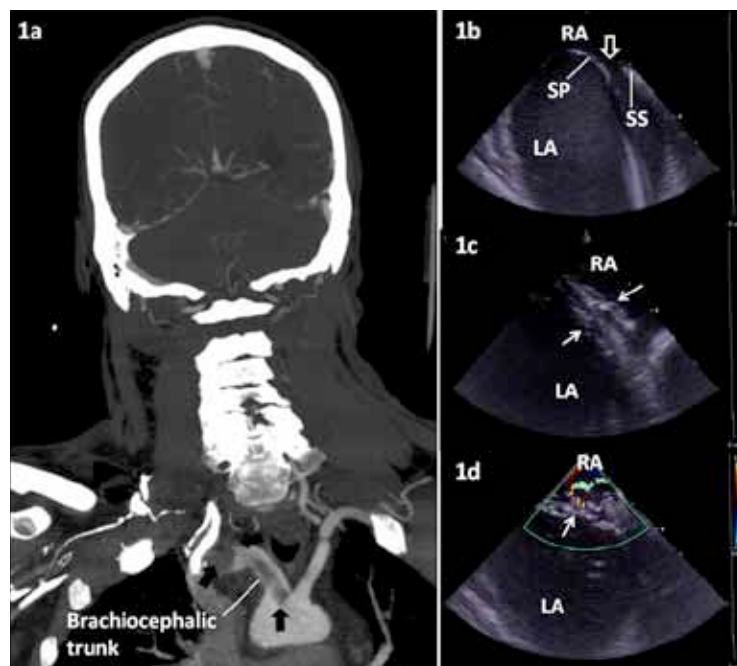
A previously fit and well 50-year-old businessman with frequent air travel history had flare-up of gout arthritis followed by right leg deep vein thrombosis confirmed on doppler ultrasound two days later. Despite anticoagulation therapy, he presented with left-sided hemiparesis five days later secondary to ischemic stroke confirmed on CT scan and was thrombolysed with alteplase therapy. A follow-up CT scan the next day showed a) extensive thrombus (black closed arrows) extending from the aortic arch into the brachiocephalic trunk causing almost complete occlusion of his right subclavian and common carotid arteries with relative reduction in the vascularity of the right hemisphere with associated edema. He required urgent decompression craniotomy 2 days later due to reduced mental state secondary to cerebral edema. Extensive investigation did not identify any coagulopathy or intracardiac embolic source. A transesophageal echocardiogram (TEE) with agitated saline and pressure on abdomen confirmed the presence of a small PFO with right-to-left shunt and no thrombus was seen in the PFO. Two weeks later, he underwent PFO closure under intracardiac echocardiography (ICE) and fluoroscopic guidance. The PFO b) measured 12 mm in diameter (white open arrow) using balloon sizing and was successfully closed using c & d) a 30-mm Gore Septal Occluder® (GSO) (white arrows) without residual shunt. He was discharged to local hospital for further rehabilitation a week later. Incidentally, this was the first clinical case of PFO closure using GSO in the world. LA, left atrium; RA, right atrium; SP, septum primum; SS, septum secundum.
